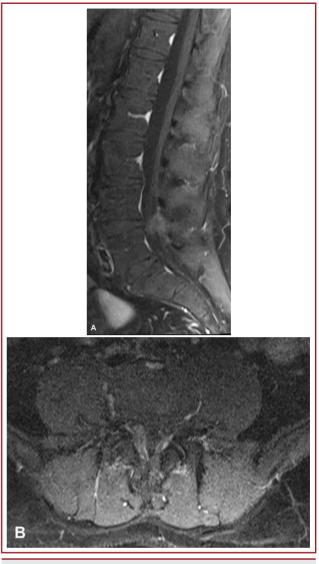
T1-weighted (a) Sagittal and (b) axial images show weak enhancement after contrast injection.
